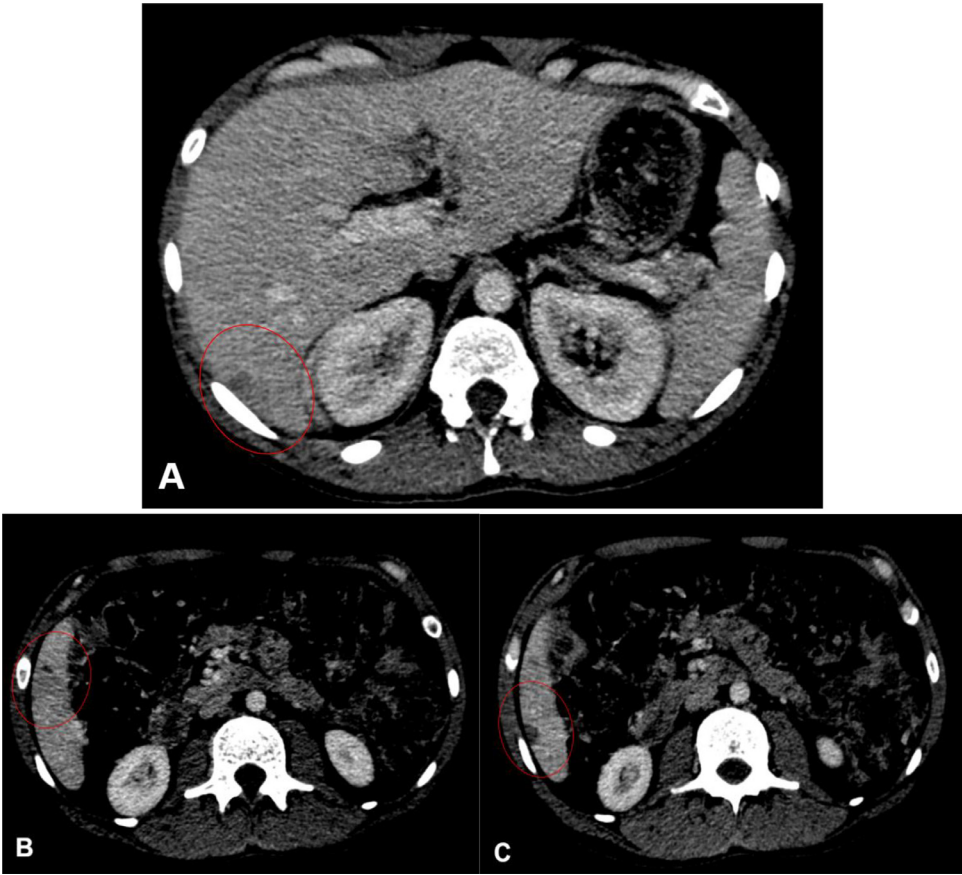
CT Portal venous phase demonstrates peripheral hypodense liver nodules (circles).
